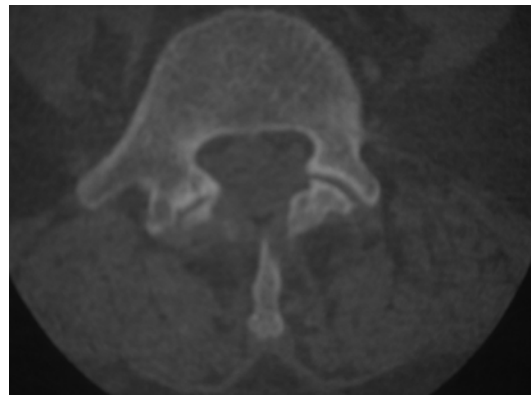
Axial CT scan demonstrating L4–5 facet joint arthritis on the right side
